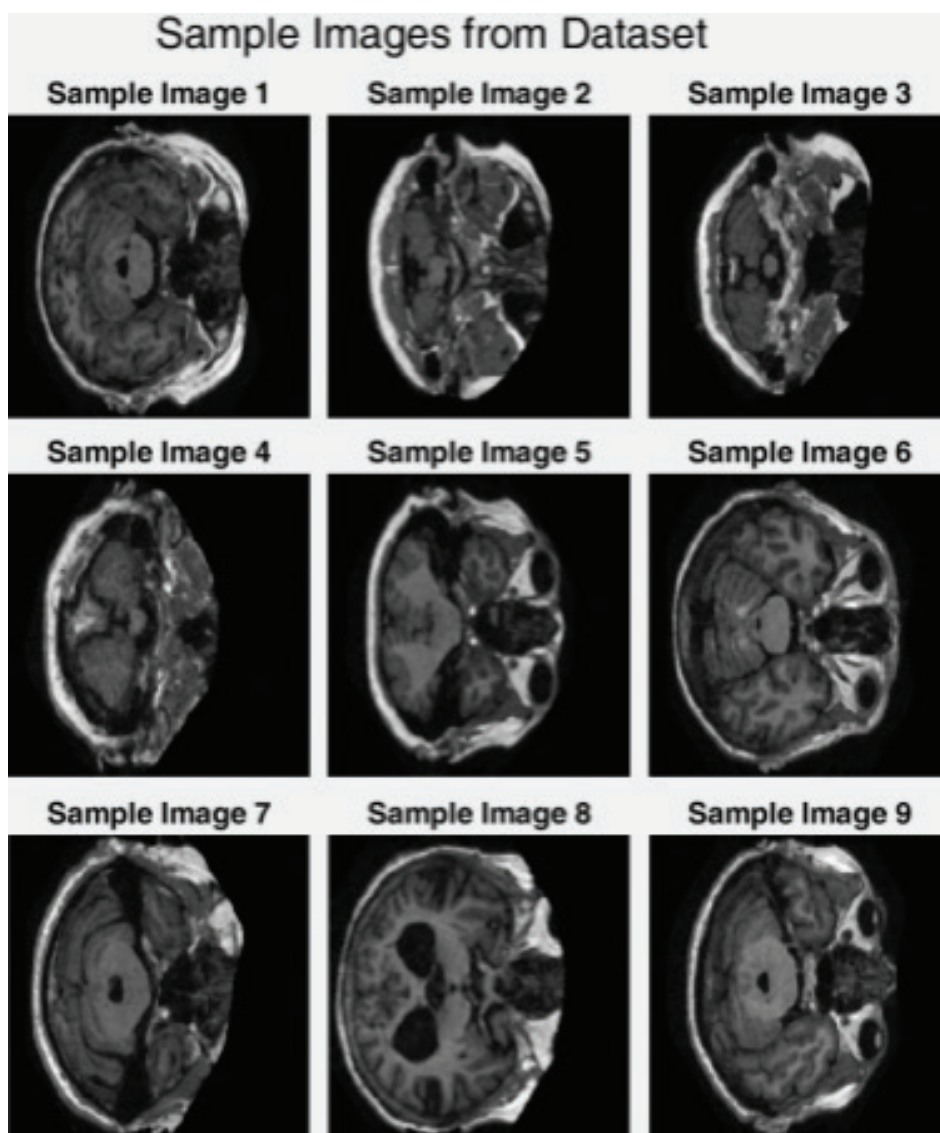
Representative MRI images. Image created by the authors.
